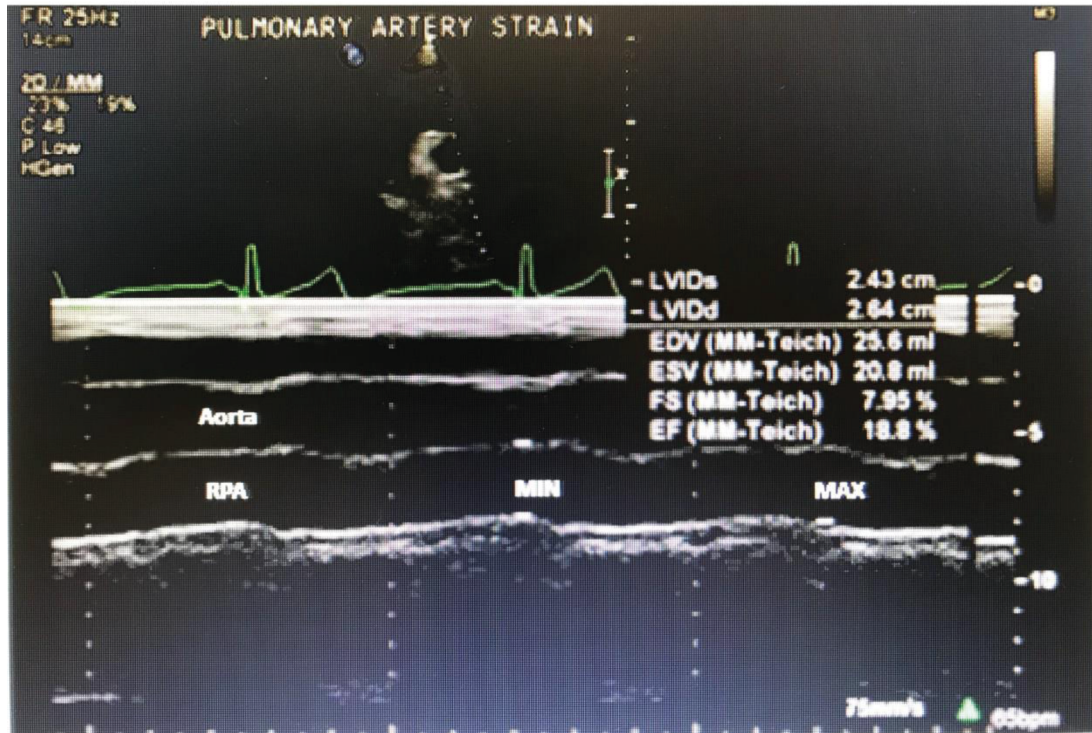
Transthoracic echocardiographic view showing measurement of pulmonary artery distensibility. RPA, right pulmonary artery; min, minimal diameter; max, maximal diameter.
